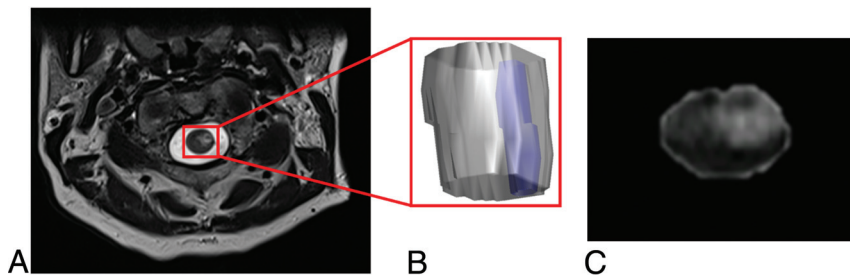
Manual-based segmentation of the hyperintense lesion area (*blue*) and the spinal cord that delineates it (*gray*) based on T2-weighted imaging.
